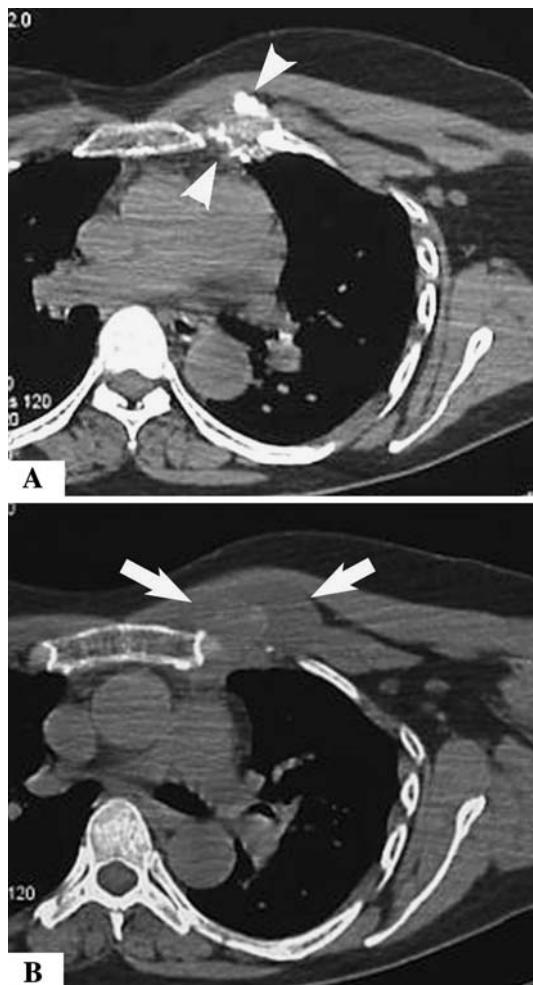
B (A) An axial CT scan of the chest (soft tissue windows) shows a mixed-attenuation mass along the anterior left chest wall involving the second and third costochondral and costosternal regions. Areas of somewhat amorphous, coarse calcification (arrowheads) and small focal areas of sclerosis involving the adjacent margins of the sternum and ribs with no gross destructive changes are seen. (B) An axial CT scan (soft tissue window) slightly more cephalad shows a more superficial, low-density or cystic component of the mass (arrows), which appears to mildly displace but not invade the overlying pectoralis major muscle.
